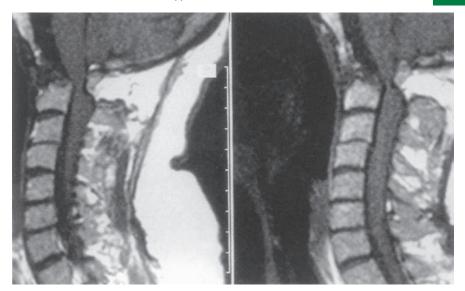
Left and right: Sagittal MRI scans in rheumatoid arthritis demonstrating destruction of the dens with compression of the medulla and spinal cord at the cranio-cervical junction.
